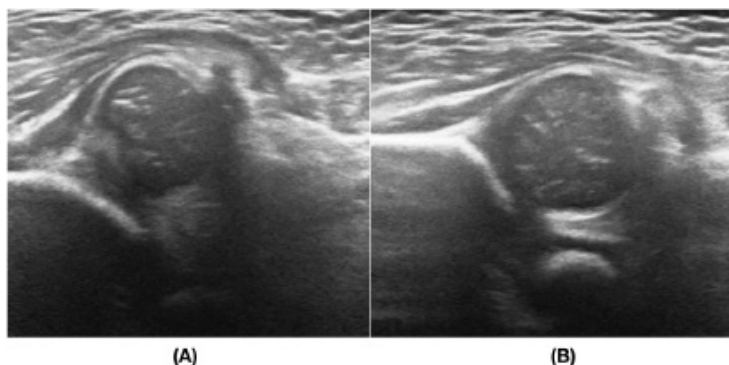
(A) An ultrasound demonstrating hip dislocation. The unossified femoral head is resting out of the bony acetabulum within the abductor muscle. This is the preferred imaging modality for children under 6 to 9 months of age. (B) By comparison, a reduced hip rests concentrically within the acetabulum.
